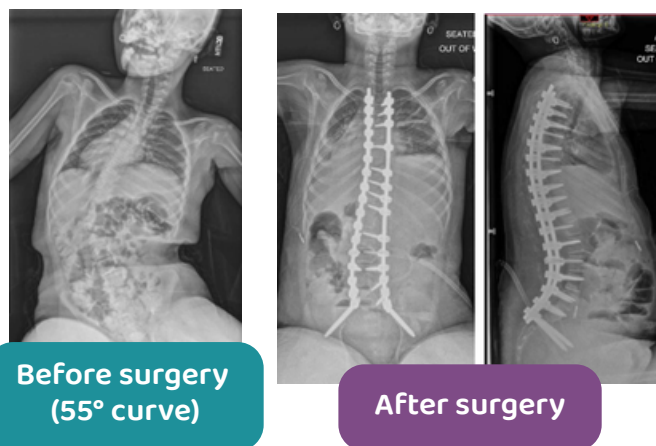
above shows X-rays from before (left image) and after (right two images) posterior spinal fusion surgery.
